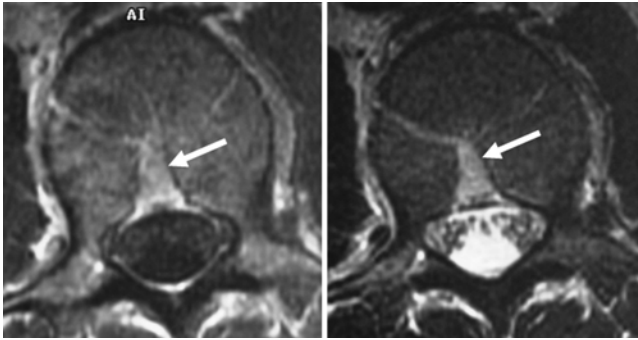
Axial T1- (left) and T2-weighted (right) MR images demonstrating prominent midvertebral body vein (arrow).
